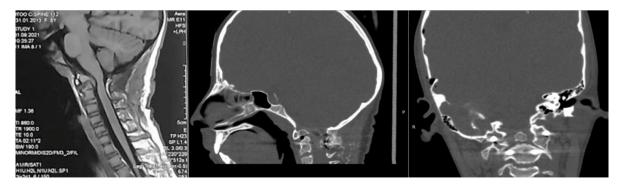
CVJ MRI (2a- sagittal) and MSCT (2b - sagittal, 2c-axial) images
